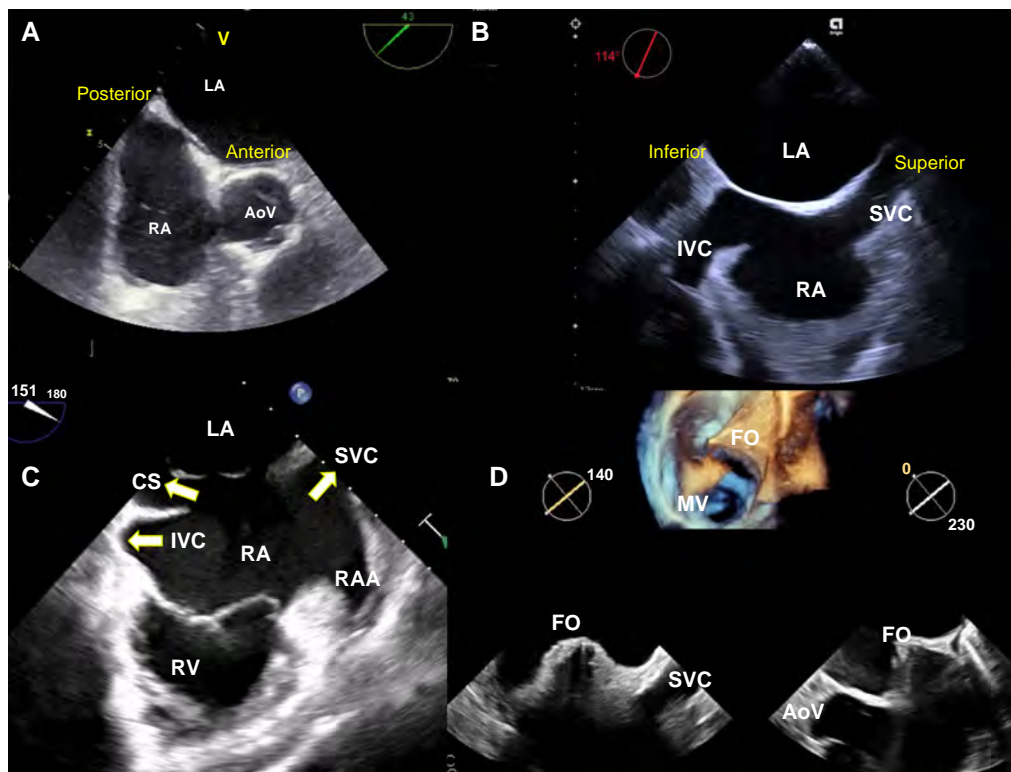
Transoesophageal echo to guide TSP. From mid-oesophageal view, the short-axis view of the aortic valve (AoV) provides the view of the interatrial septum spanning anteriorly and posteriorly (A) whereas from the bicaval view, the interatrial septum is visualized along the superior and inferior axis with the superior (SVC) and the inferior (IVC) venae cavae as landmarks (B). It is important to differentiate between the IVC and the coronary sinus (CS) which starts at the level of the septum. The Eustachian valve can be used as landmark to differentiate between both structures (C). (D) The simultaneous biplane view of the interatrial septum (bicaval view on the left and short-axis view on the right) and the three-dimensional volume rendering on top to see how the puncture is performed visualized from an en-face view of the right and left atrium. The puncture is performed through the fossa ovalis in a rather floppy septum. AoV, aortic valve; CS, coronary sinus; FO, fossa ovalis; IVC, inferior vena cava; LA, left atrium; MV, mitral valve; RA, right atrium; RAA, right atrial appendage; RV, right ventricle.
